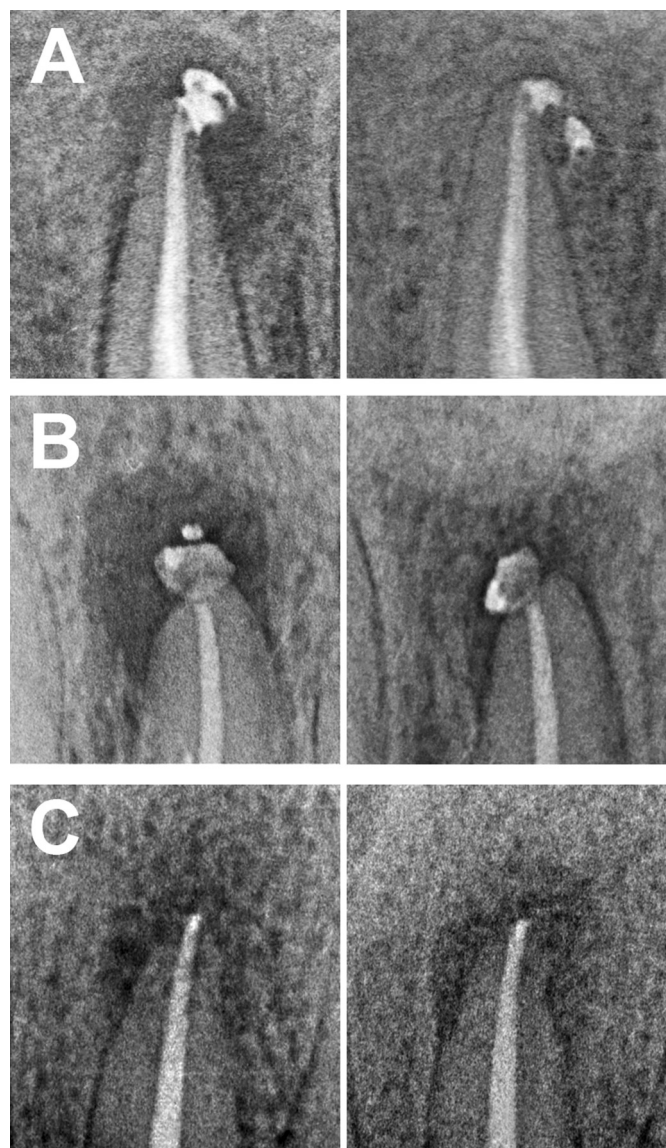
Representative radiographic appearance of the apical area of the three scores at baseline and recall: (A) healing, complete bone regeneration around the apex; (B) improvement, lesion reduced in size; and (C) failure, increase of lesion size or absence of changes from the initial status.
